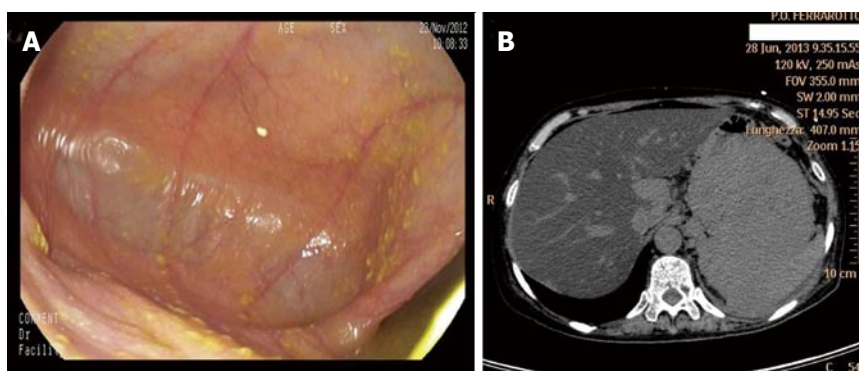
Extra-medullary plasmacytoma with gastric localization arising after treatment for multiple myeloma. A: Gastroscopy resulted negative for tumor detection; B: CT scan analysis of the upper abdomen showing a bulky mass departing from the stomach.
